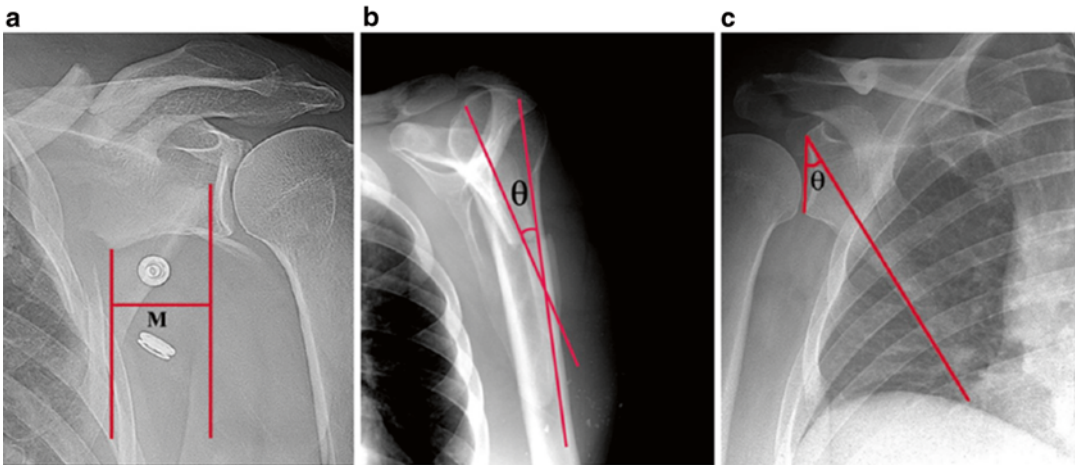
(a–c) Initial measurement of displacement for scapular body fractures occurs, utilizing 2D radiographs. Medialization or lateral offset (a), angulation (b), and glenopolar angle (c) measurements are shown here
